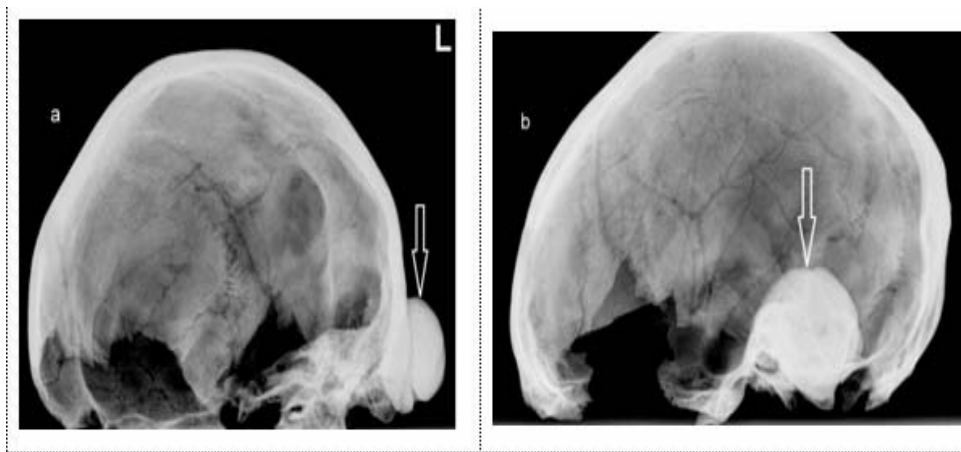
Radiography (X-ray photo): mastoid osteoma at the left temporal bone (R12, ♂, 55–60 year-old); (a) antero-lateral view; (b) lateral view.
